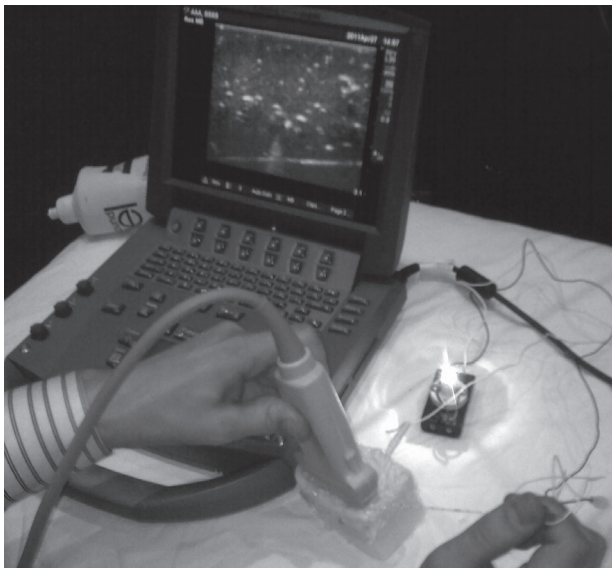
Practicing for interventional ultrasound using cheese, inside which there is a metal pin linked to an electric circuit. A needle linked to the same circuit is inserted under ultrasound guidance. The participant being observed has precisely touched the metal pin with the tip of the needle, and thus succeeded in lighting the small lamp by completing the electrical circuit.
